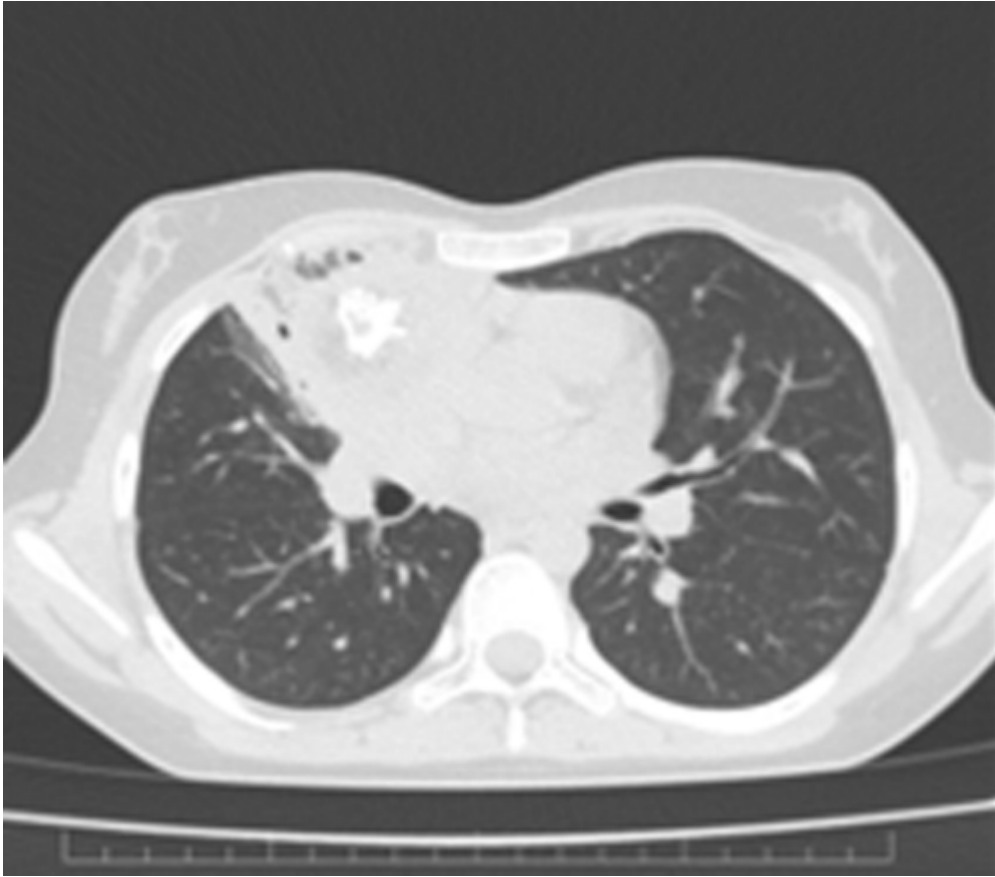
Chest CT. The left upper lobe is hypodense, in keeping with a small, incidental focus of bronchial atresia. ↩
